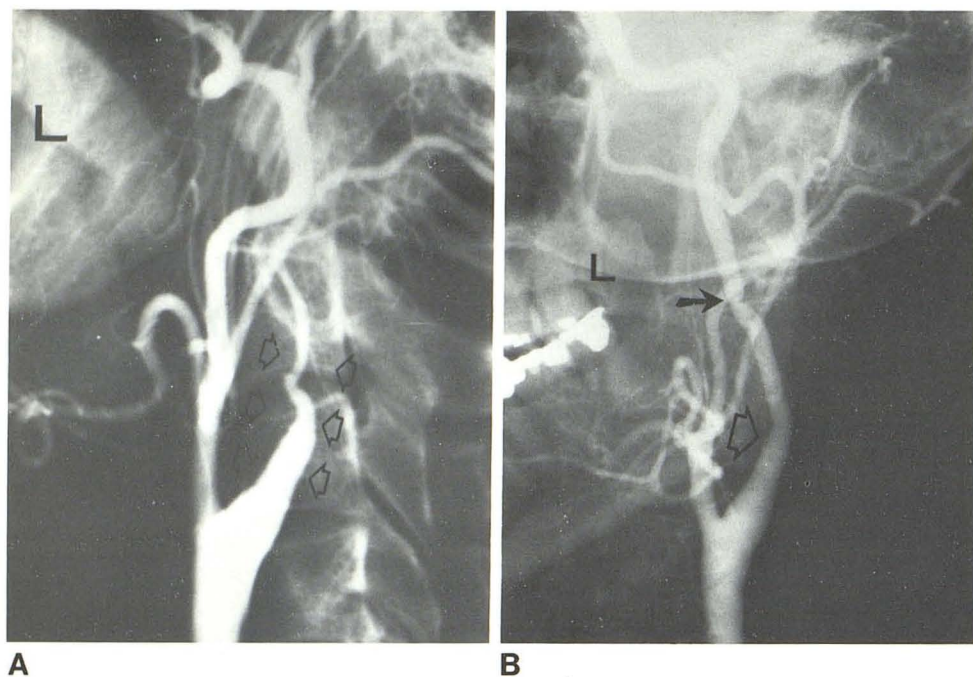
Case 3, 46-year-old woman with left-sided amaurosis fugax. Left common carotid angiograms. A, Lateral view. Tapered high-grade stenosis of internal carotid artery (arrows). Maximal stenosis was immediately distal to carotid sinus region. Proximal vessel lumen has no atheromatous plaque disease and distal cervical and intrapetrous carotid lumen appeared normal on serial radiographs. B, Oblique, anteroposterior view 2 months later. Nearly complete resolution. Normal area of maximal stenosis (open arrow). Persistent wedgelike defect (solid arrow) remains, presumably demarcating junction between intramural dissecting hemorrhage and normal vessel wall.
